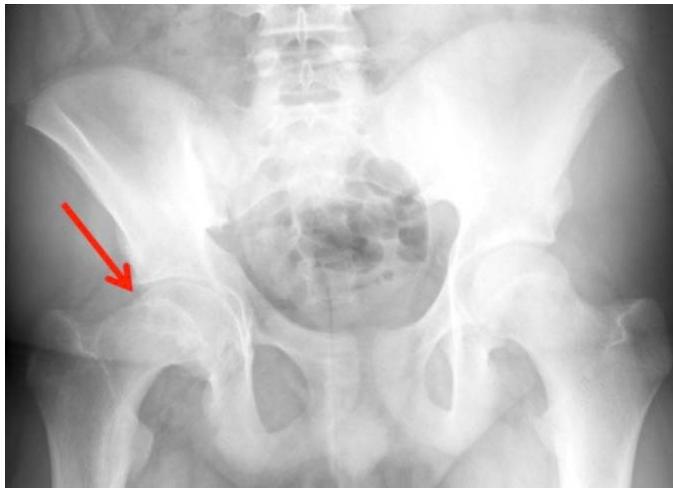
AP x-ray left slipped capital femoral epiphysis
